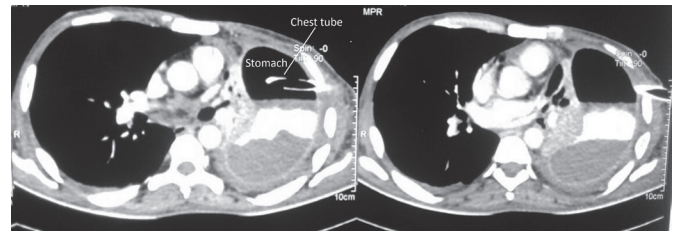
(a-b) Axial sections of the computed tomography of chest.
